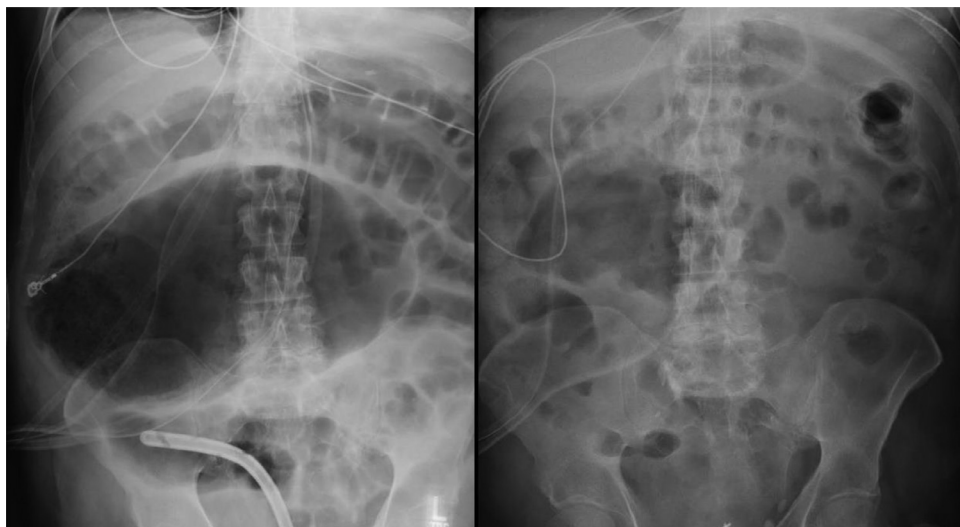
Supine radiographs demonstrating a dilated cecum which markedly improved after colonoscopic decompression.
